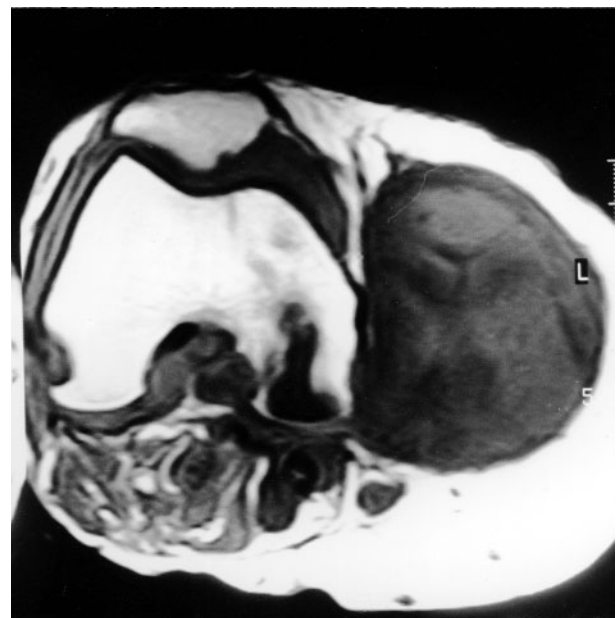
MRI of an extraarticular knee cyst communicating with the joint space (A). Several other smaller cysts with similar signal intensity were located in the popliteal region (B).
